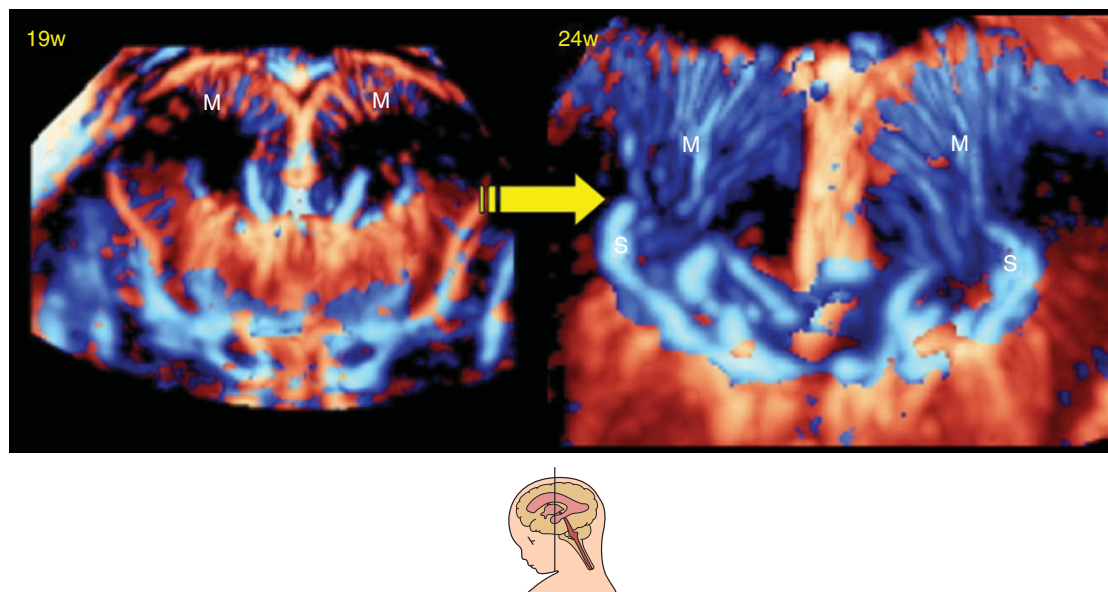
Development of medullary vessels with advanced gestational age. 3D reconstructed coronal power Doppler images from the same fetus at 19 postmenstrual weeks of gestation (A) and 24 postmenstrual weeks (B). At 19 postmenstrual weeks, medullary vessels (M) are immature, and most of the veins run toward the pia mater. With advancing gestational weeks, medullary vessels (M) mature and increase in numbers. The vessels run in the central direction from the cerebral cortex toward the longitudinal caudate vein of Schlesinger (S).
